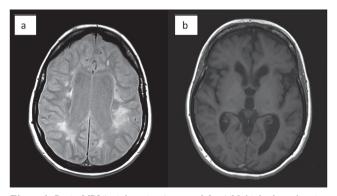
Brain MRI (axial sections), case $n^o 1$: a) Multiple demyelinating lesions, Some confluent and an extensive lesion in the left parietal region in T2 weighted sequences; y b) marked cerebral atrophy in T1 weighted sequences
